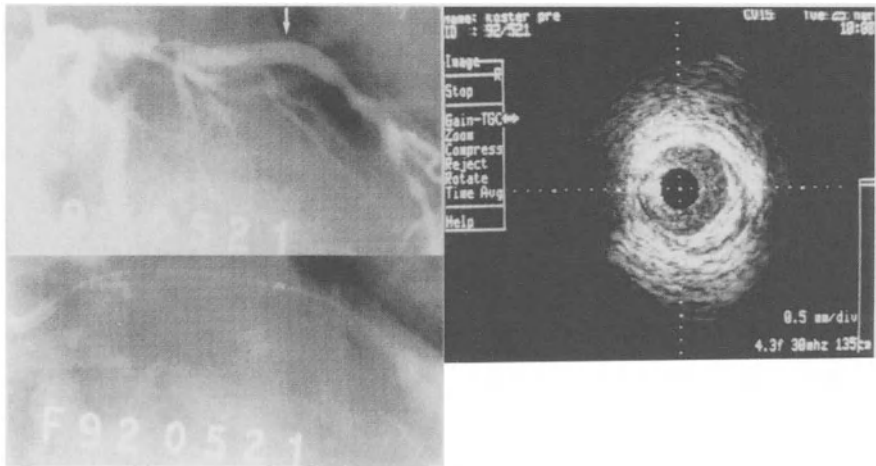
Left upper panel: Coronary angiogram of left anterior descending artery with severe proximal lesion and angiographically normal mid segment. Left lower panel: intravascular ultrasound device inserted into mid segment of left anterior descending artery, at the same level of white arrow. Right panel: ultrasound image obtained at site of arrow. There is an intimal plaque extending from 2 to 6 o'clock.
